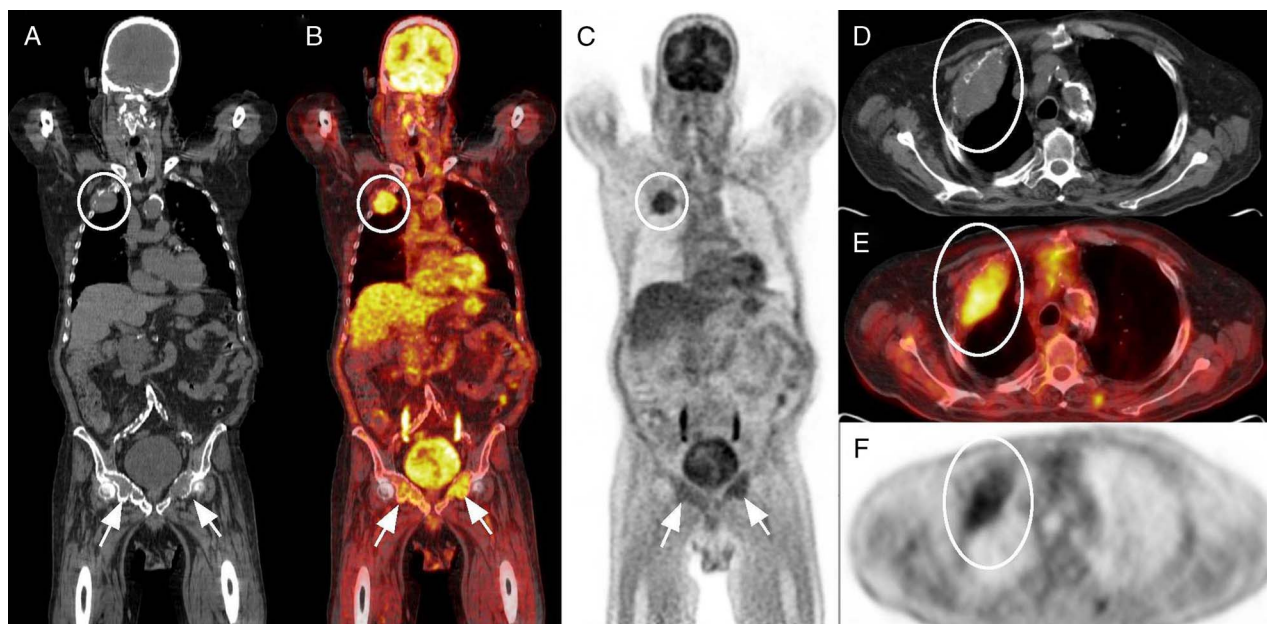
Additional images for the 77-year-old man with MM and multiple expansive lesions in the right ribs shown in Figure 2 are presented here. ¹⁸F-FDG PET/CT demonstrated a destructive lesion with soft tissue mass in the right second rib with increased ¹⁸F-FDG metabolism (SUVmax 4.5), as shown in the coronal and axial CT (A, D), fused ¹⁸F-FDG PET/CT (B, E), and ¹⁸F-FDG PET (C, F), respectively. The patient died after 3 cycles of chemotherapy due to treatment complications.
